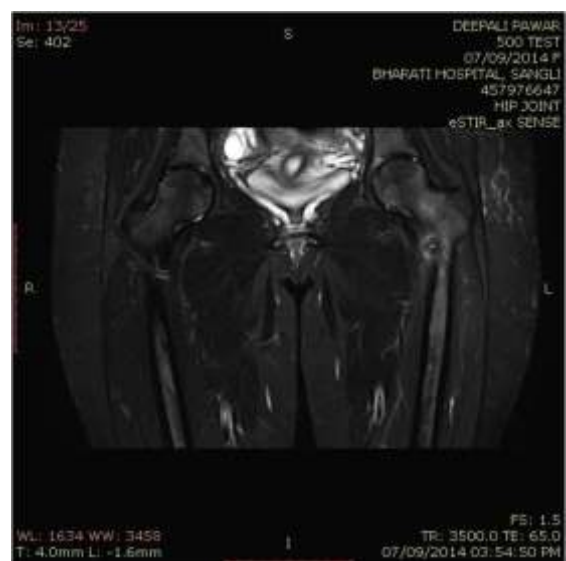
Follow-up MRI shown Air in the Nidus Show mild Sclerosis of the Nidus.
